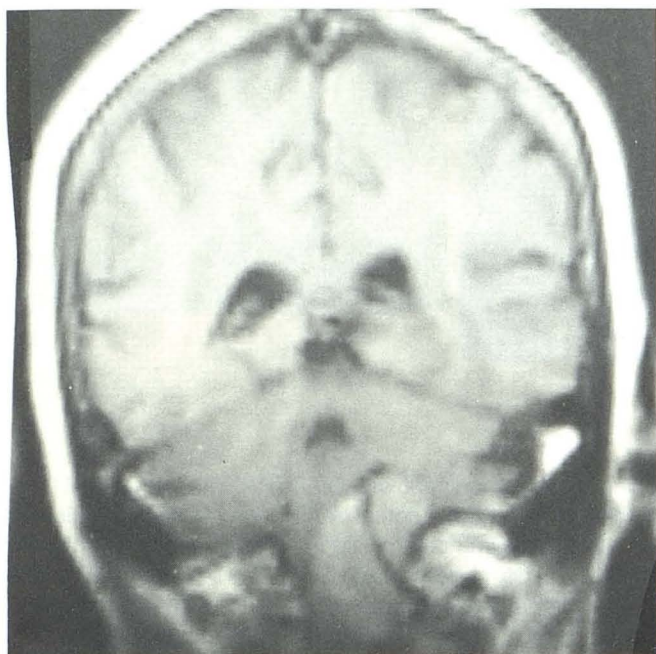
67-year-old woman with meningioma of foramen magnum. MR image (TR = 500, TE = 30 msec) after Gd-DTPA shows enhancing lesion, with vertebral artery within it seen because of signal void from rapid flow.
